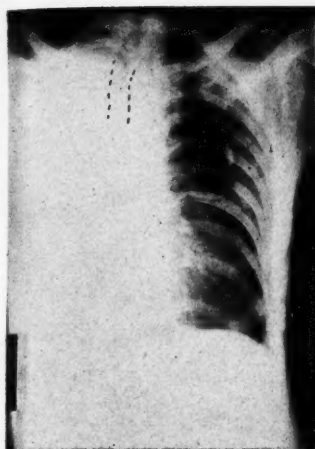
Case 3. On the seventh post-operative day after kidney fixation operation, patient complained of pain in chest, and cough. Radiographic examination made at this time showed dense consolidation of entire left chest, approximation of interspaces and narrowing of chest cavity, displacement of trachea and heart toward involved side.
